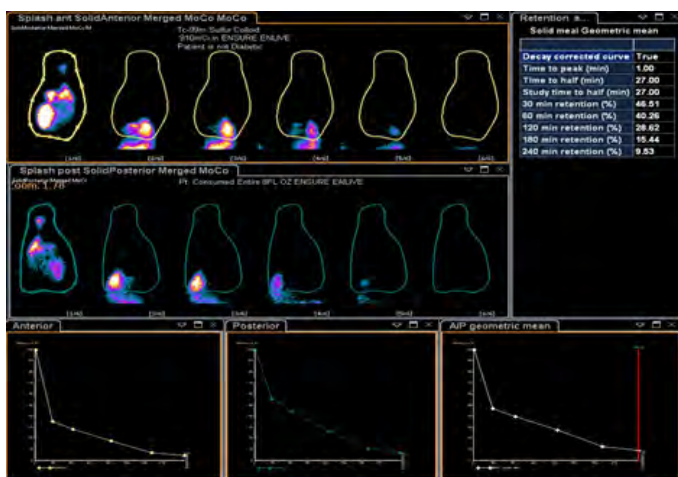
Regions of interest (ROIs) from a scintigraphic GE initial interpretation described early emptying of labeled supplement in the small bowel indicating the diagnosis of rapid gastric emptying with a calculated retention of only 46.51% (normal >70%) at 30 minutes.
